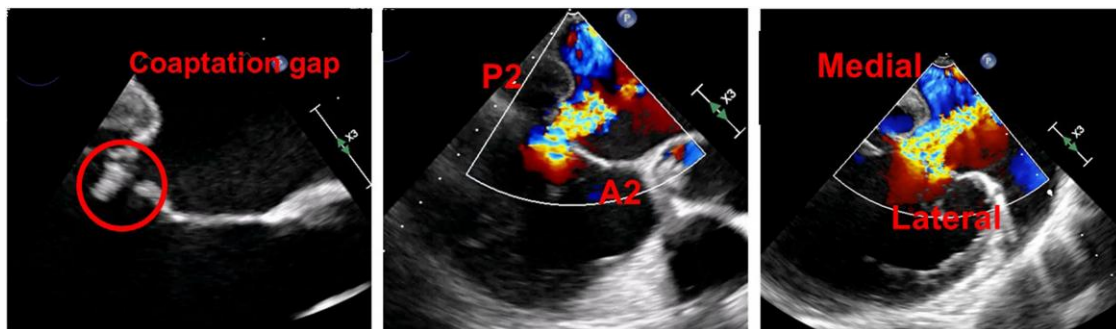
Transoesophageal echocardiographic findings before transcatheter edge-to-edge repair and Impella insertion in Patient 1.
